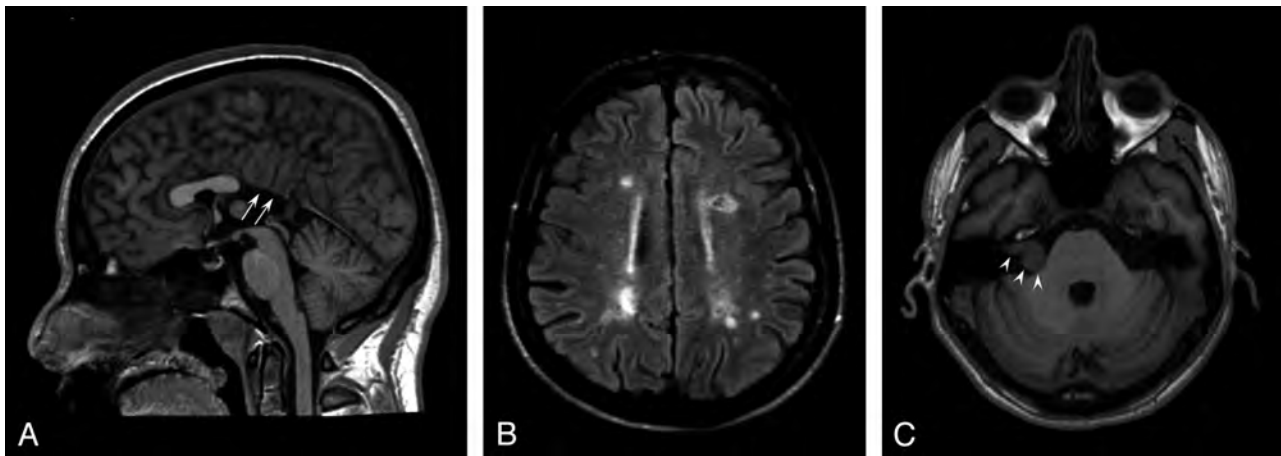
Conventional brain MR imaging findings in 45 patients with Kallmann syndrome. *A*, Midsagittal T1-weighted image of a patient with agenesis of the posterior portion of the corpus callosum (*white arrows*). *B*, Axial FLAIR image of the patient disclosing several multiple sclerosis–like white matter signal abnormalities in the centrum semiovale bilaterally. *C*, Non-enhanced axial T1-weighted image at the level of the internal acoustic meatus showing a right intra/extrameatal dumbbell-shaped mass consistent with an acoustic schwannoma.
